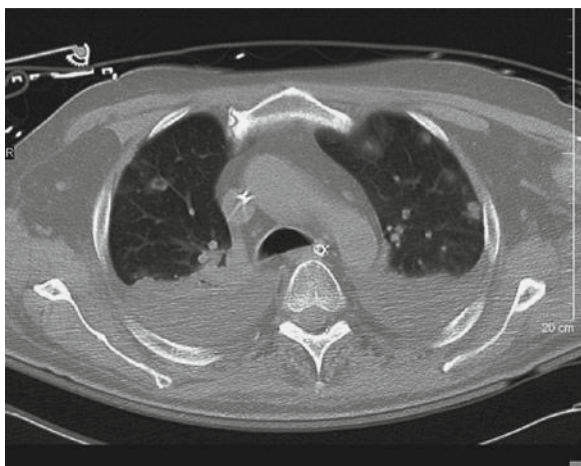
CT scan of the chest showing multiple peripheral nodules, some with cavitation, consistent with septic pulmonary emboli in a HSCT recipient with methacillin resistant *S aureus* bacteremia secondary to indwelling central venous catheter
